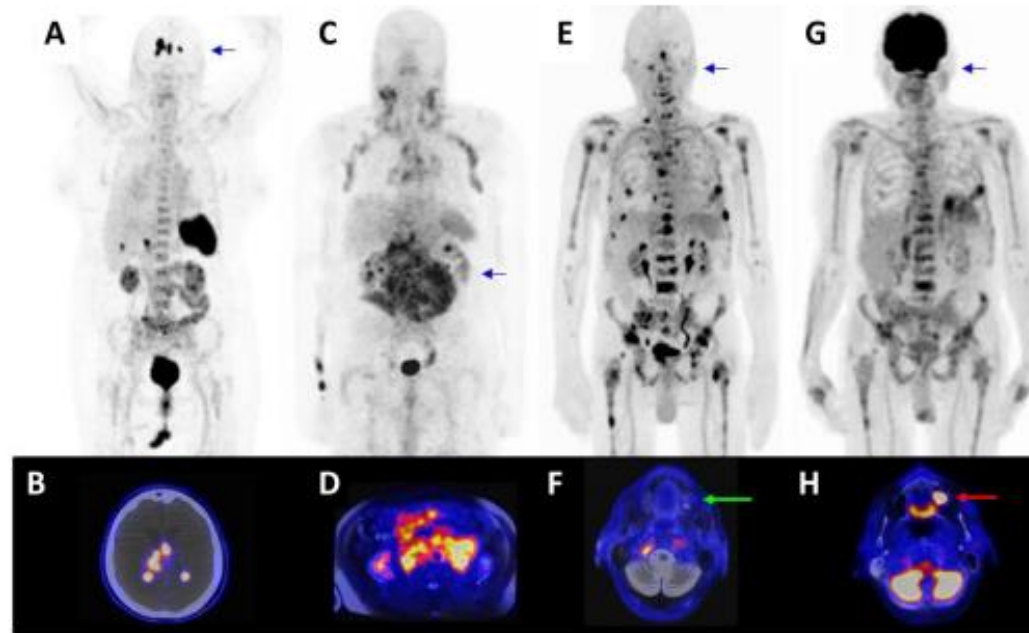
[⁶⁸Ga]Pentixafor-PET/CT in patients with lymphoproliferative malignancies. A) [⁶⁸Ga]Pentixafor- PET/CT in a patient with relapsed diffuse large B-cell lymphoma (PET MIP) with B) transaxial PET/CT image at the level of the brain. C) [⁶⁸Ga]Pentixafor-PET/MR in a patient with chronic lymphocytic leukemia and suspected transformation into aggressive B-cell lymphoma (PET MIP) with D) transaxial PET/MR image at the level of the kidneys. E) [⁶⁸Ga]Pentixafor PET/MR in a patient with multiple myeloma (PET MIP) with F) transaxial image at the level of the maxilla demonstrated no uptake in the maxilla (green arrow). G) Corresponding [¹⁸F]FDG PET/MR (PET MIP) of the patient depicted in E) and F) with corresponding H) [¹⁸F]FDG PET/MR transaxial image at the level of the maxilla (red arrow, same region as depicted in F) showed [¹⁸F]FDG uptake in the maxilla/ floor of the maxillary sinus, most likely caused by a dental infection.
